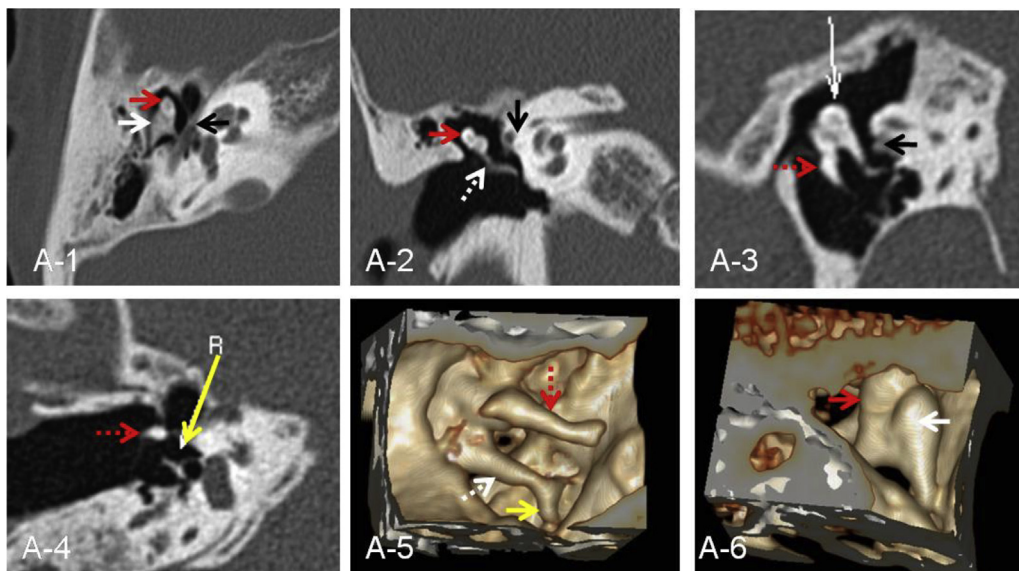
Axial (A-1) and coronal section planes of conventional CT show the head of malleus (red arrow) and incus (white arrow). A-3 & A-4 are MPR images showing the whole intact ossicular chain. A-5 and A-6 are CTVR imaging. Red arrow—head of malleus; red dotted arrow—handle of malleus; white arrow—body of incus; white dotted arrow—long limb of incus; yellow arrow—normal stapes superstructure; black arrow—facial nerve.
